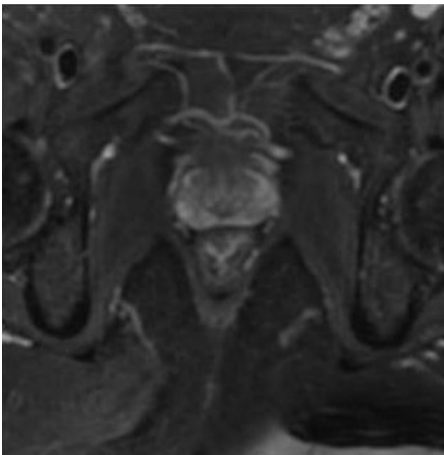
Axial T2-weighted image with fat saturation. Intersphincteric fistula with normal appearance of the ischioanal space
